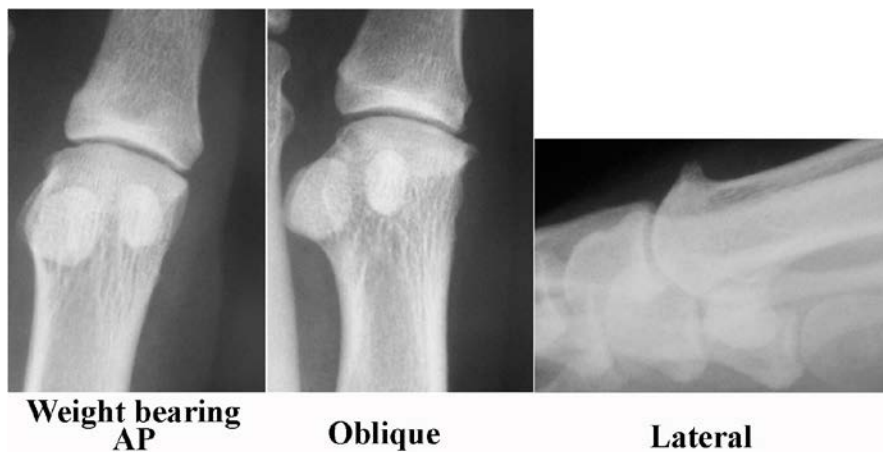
Radiographs demonstrating poor agreement case for hallux rigidus.
